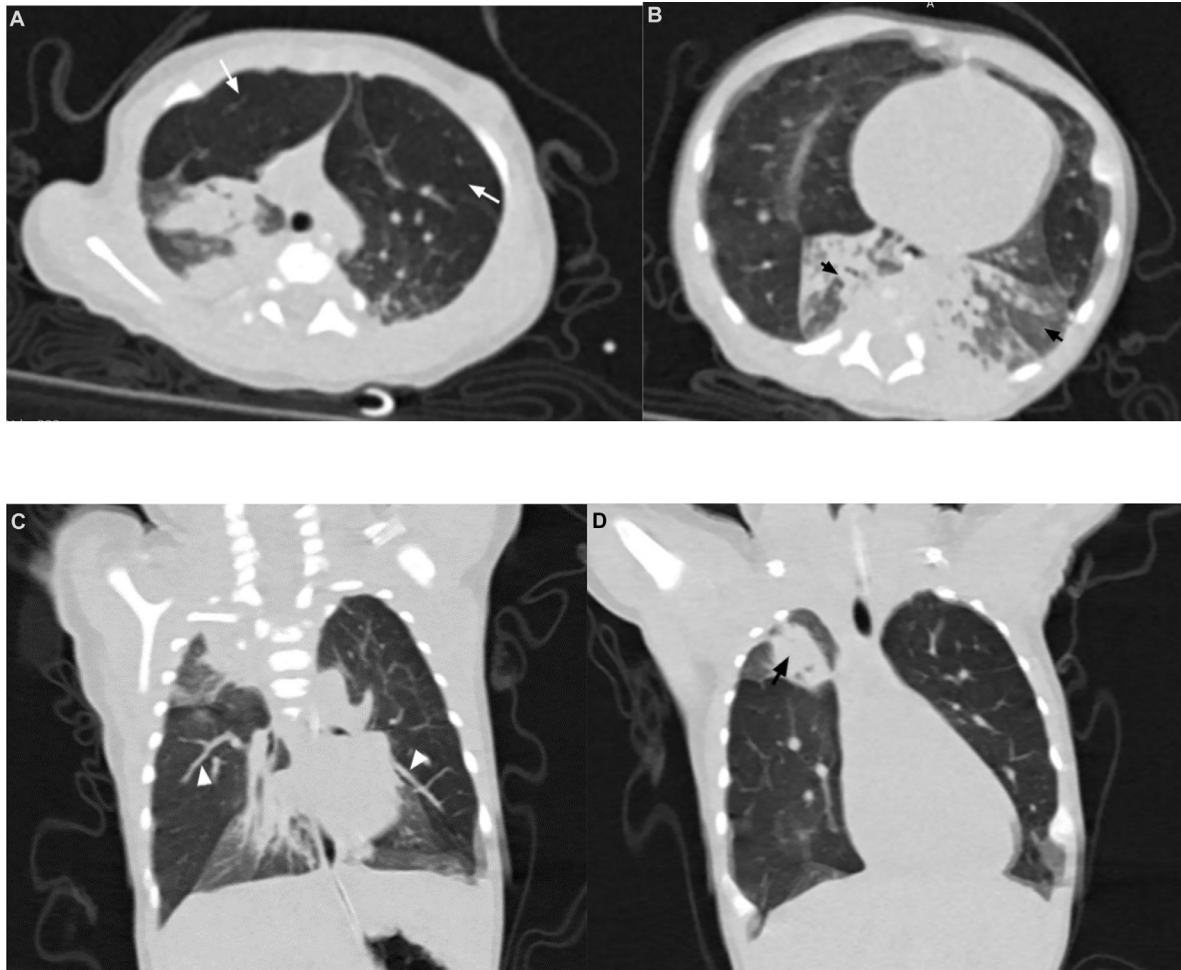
Three days later, axial cranial (A) and caudal (B) sections of lung window chest CT show air trapping in the right middle and left upper lobes (white arrows in A) with bibasal lung collapses (black arrows in B). Coronal views (C and D) show RML and LUL disease distribution to better advantage. White arrowheads (in C) point to subjectively prominent appearing vasculature. Black arrow (in D) shows the right upper lung collapse with a focus of consolidation.
